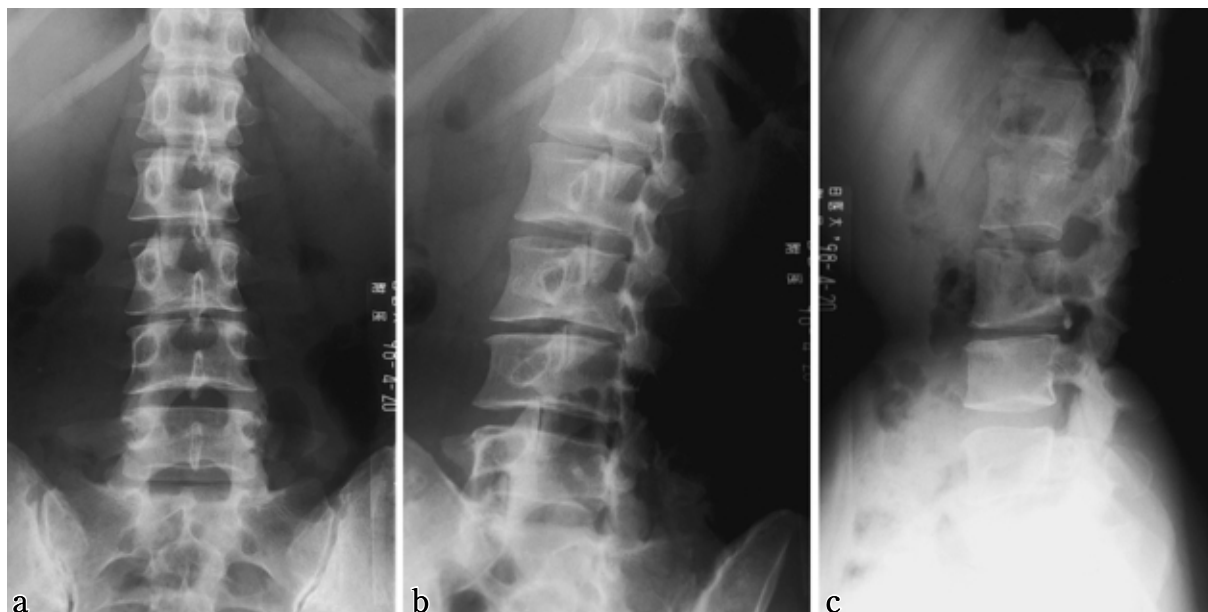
Radiographs at first visit to our hospital (March 1998). X-ray examination reveals disc space narrowing of L 3/4 associated with apophyseal separation of the vertebral body. Fig. 1-a: AP view, Fig. 1-b: Oblique view, Fig. 1-c: Lateral view
